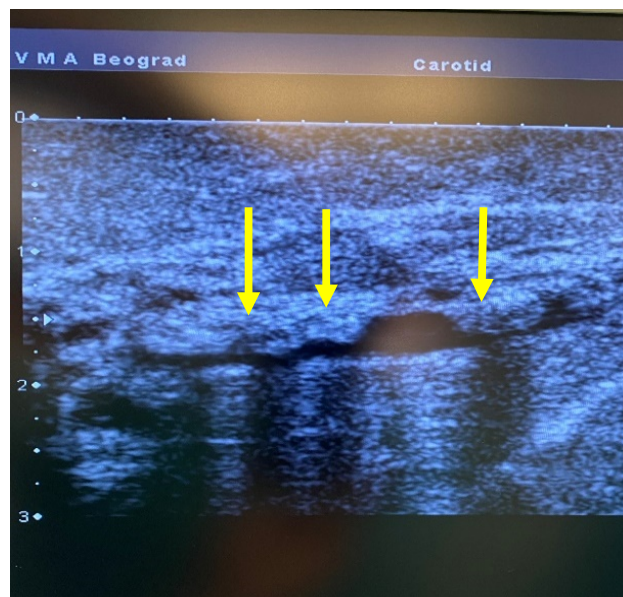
Intraoperative ultrasound with visible calculi in the intrahepatic bile ducts.
